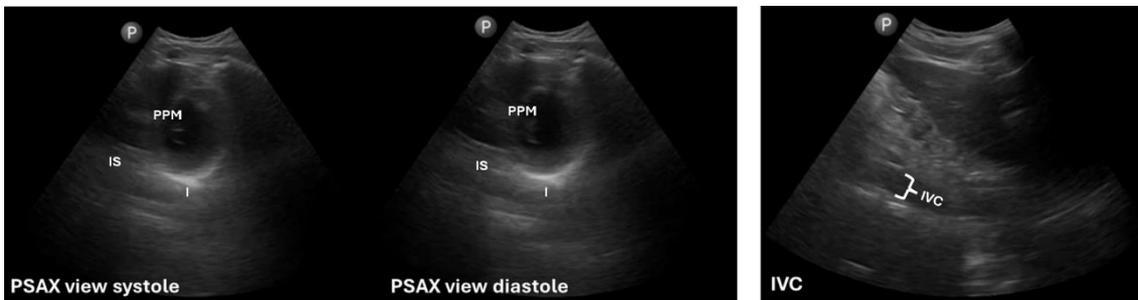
Bedside Echocardiography Demonstrating Regional Wall-Motion Abnormalities
